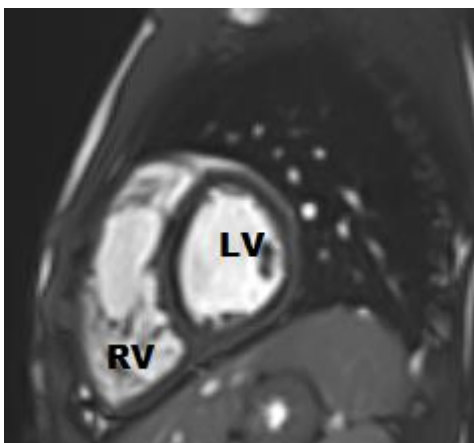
Cardiac MRI short axis view for evaluation of the interventricular septal flattening.
